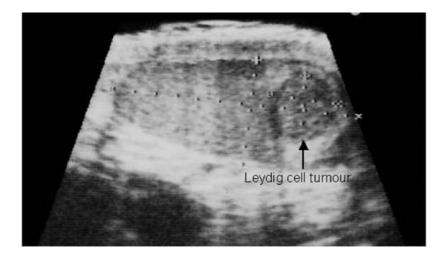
Ultrasound examination of the left testis of a 45-year-old man referred due to gynaecomastia. The ultrasound examination clearly showed a tumor formation 1.3 cm in diameter and well defined from the surrounding normal looking tissue close to the bottom of the testis (arrow). Using the Prader ochidometer the testis was estimated to be approximately 12-15 ml in size. It was soft in consistency but without palpable tumor. Sex hormone levels indicated the presence of a Leydig cell tumor, which was confirmed after isolated removal of the tumor. Following operation sex hormone levels normalized and gynaecomastia regressed.
